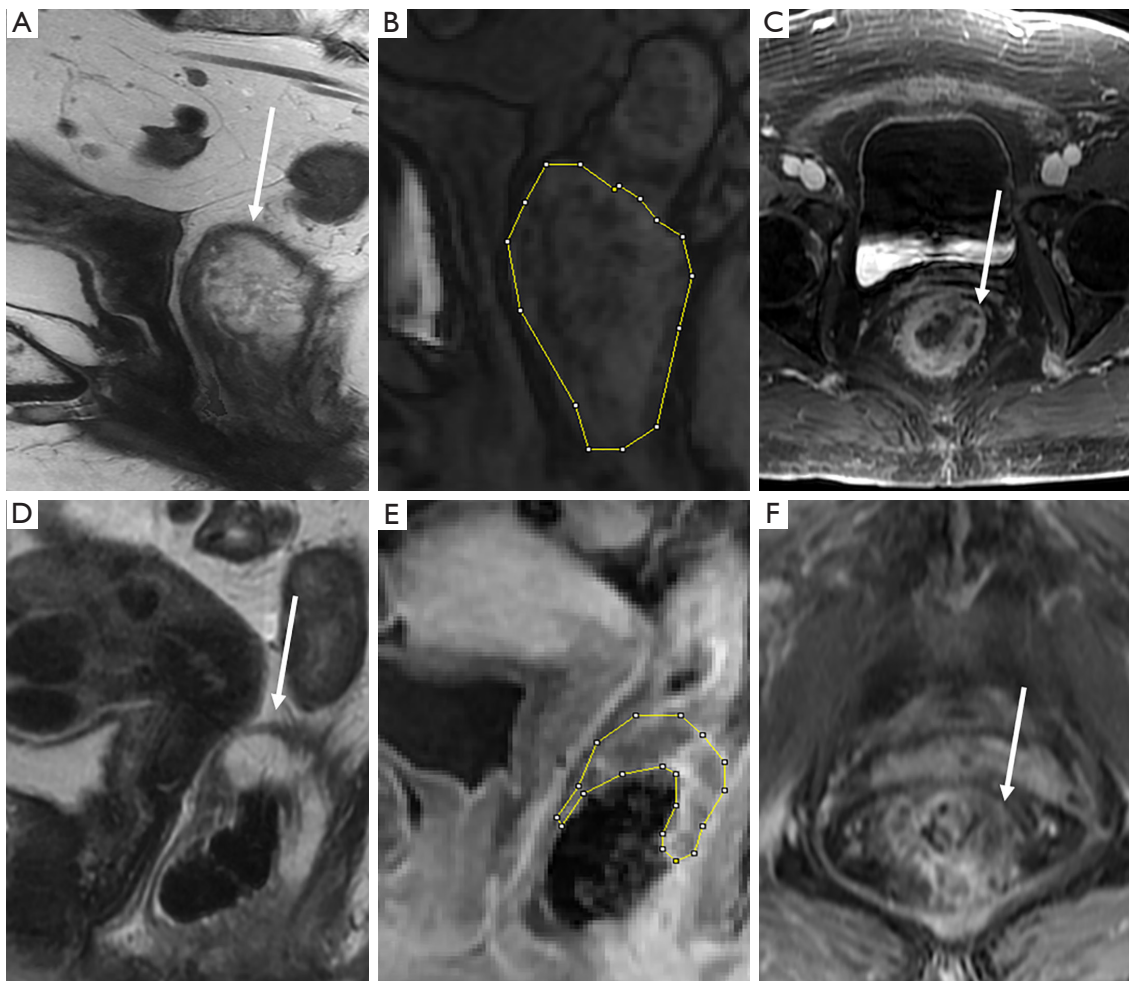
A 73-year-old woman with mucinous rectal cancer. Baseline, pre-neoadjuvant chemoradiation therapy MRI (A) sagittal T2-weighted image; (B) sagittal T1-weighted image, and (C) contrast-enhanced axial 3D T1-weighted image show a mid-rectal mucinous tumor (arrows). Post neoadjuvant chemoradiation therapy (D) sagittal T2-weighted image, (E) sagittal T1-weighted image, and (F) contrast-enhanced axial 3D T1-weighted image show decreased tumor size (arrows) with persistent mucinous component demonstrating heterogenous enhancement. Pathology showed 60% treatment response. MRI, magnetic resonance imaging; 3D, three-dimensional.
